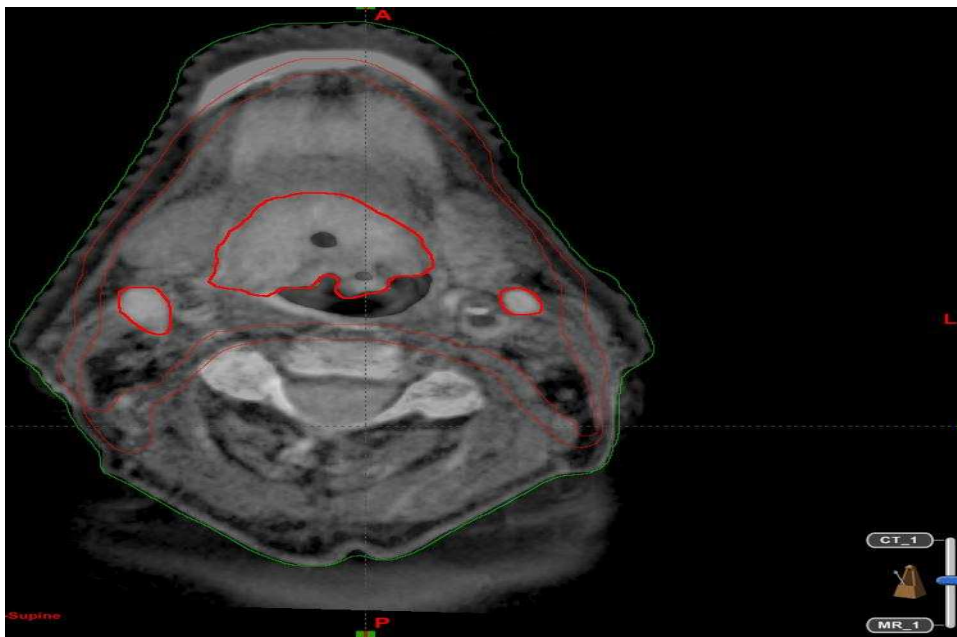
CT–MRI image fusion: delineation of GTV (red line) could be determined by MRI and directly transferred to the treatment planning CT system: Image obtained for one representative patient (oropharyngeal cancer T4 N2c) included in the study.
